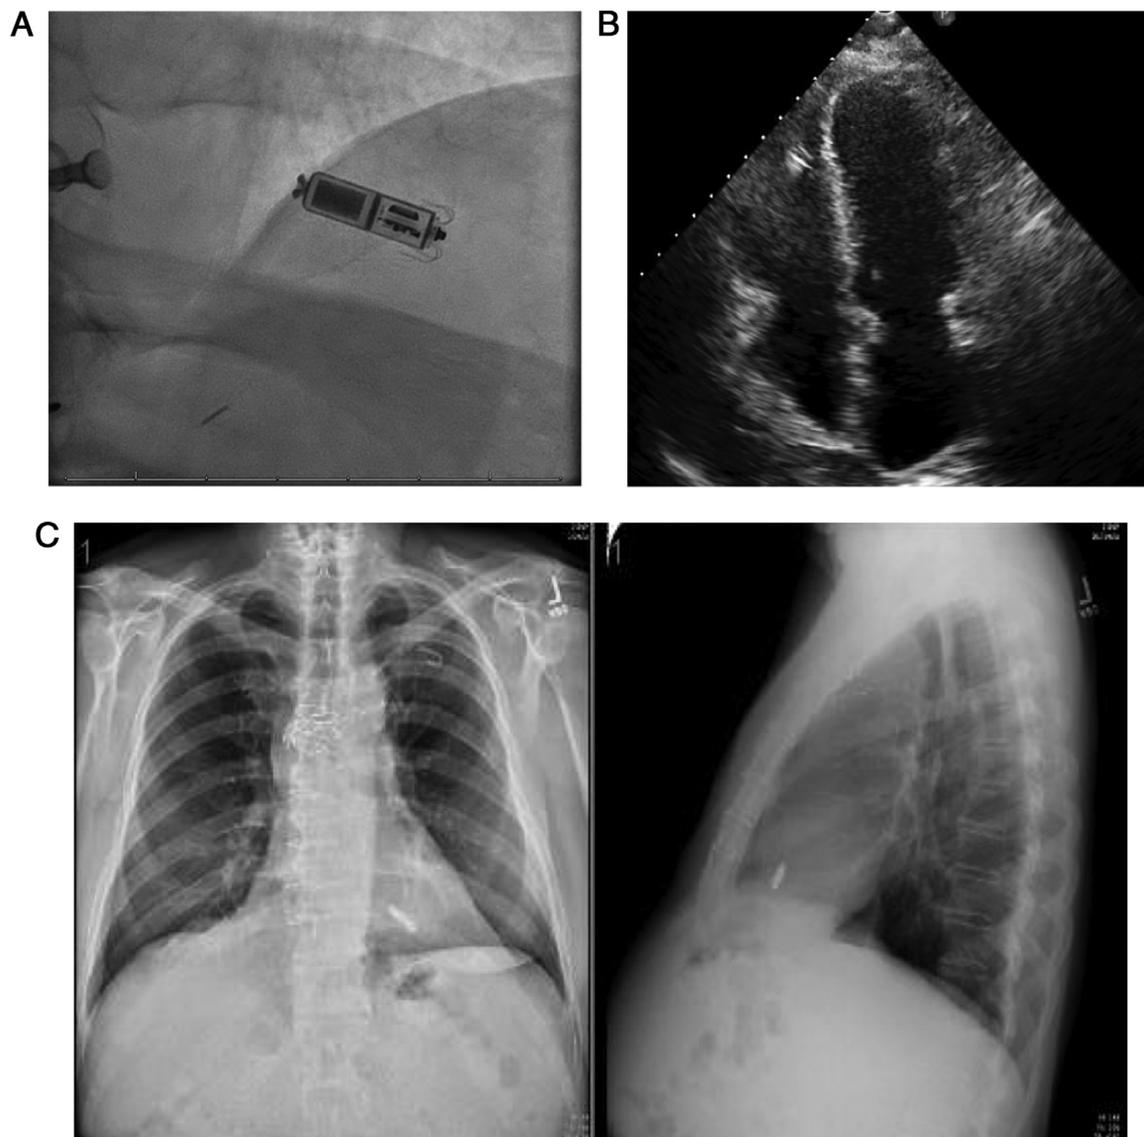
The Micra leadless pacemaker (A) at deployment (B) echocardiographic appearance at the RV apical septum (C) radiographic appearance.
